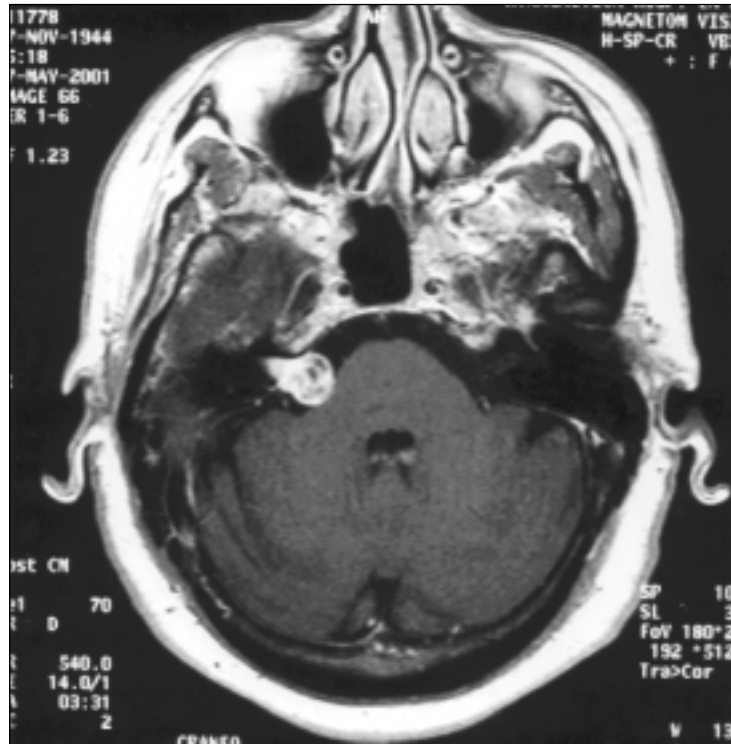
Axial MRI scan showing a 12x20 mm CPA mass with intracanalicular extension. The mass suggested a vestibular schwannoma. FN was identified intraoperatively as the origin of the tumor.
